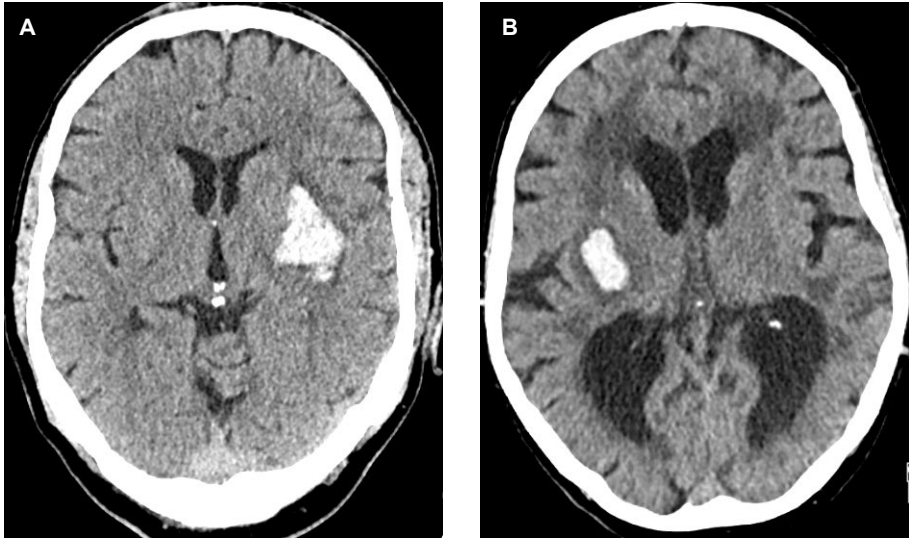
Examples of brain CT scans from patients with ICH with A) minor WML changes (modified van Swieten 2), and B) extensive WML changes (modified van Swieten 8).
